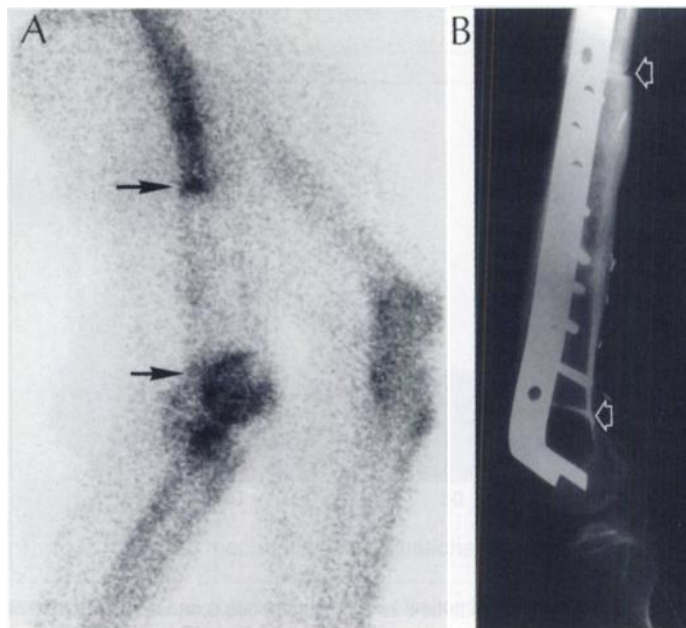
(A) Focal hyperactivity at osteotomy sites remaining 1 yr after operation as viewed by lateral scintigrams (closed arrows). (B) Corresponding radiographic image shown for comparison (open arrows indicate osteotomy sites).
